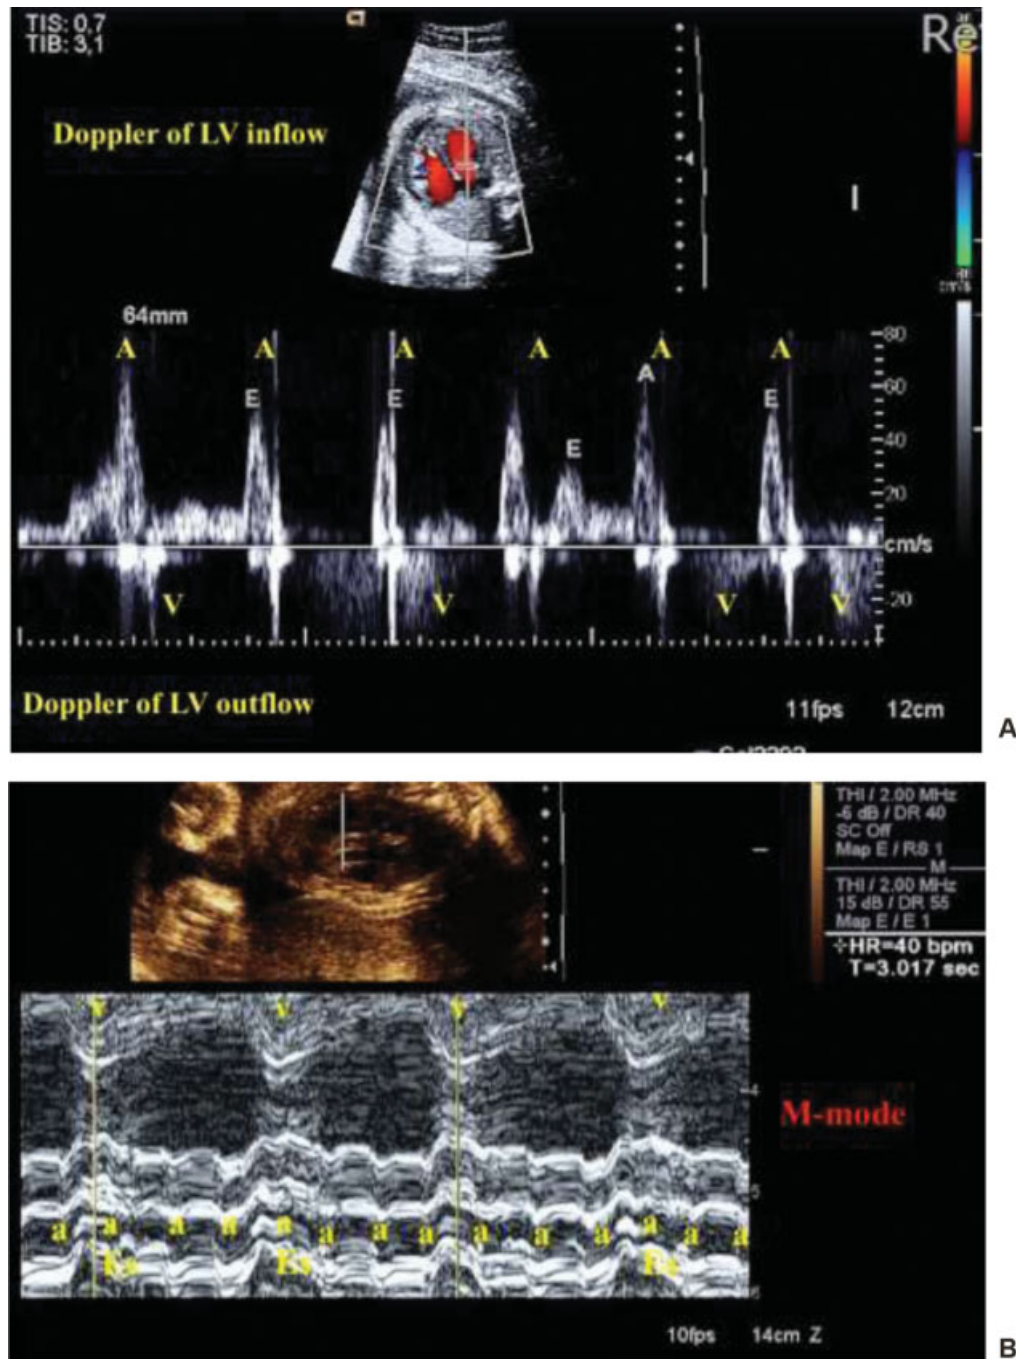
(A) Left inflow and outflow tract view showing complete atrioventricular (AV) block by analysis of the inflow and outflow tract Doppler waves. (B) M-mode ultrasound showing complete AV block by atrial and ventricular wall movement recordings. Note presence of atrial extrasystoles. Abbreviations: A: atrial contraction; V: ventricular contraction; aEs: atrial extrasystoles; HR: heart rate.
